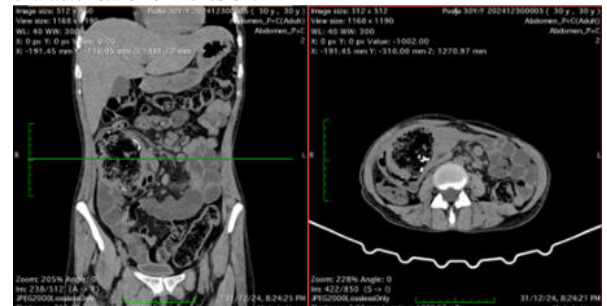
On A Plain CT Scan, Diffuse Thickening Of The Ileal Loops Was Noted, Along With An Ill-defined Mass With A Spongiform Pattern And Gas Bubbles. A Hyperdense String-like Structure Is Also Noted Within The Mass.
